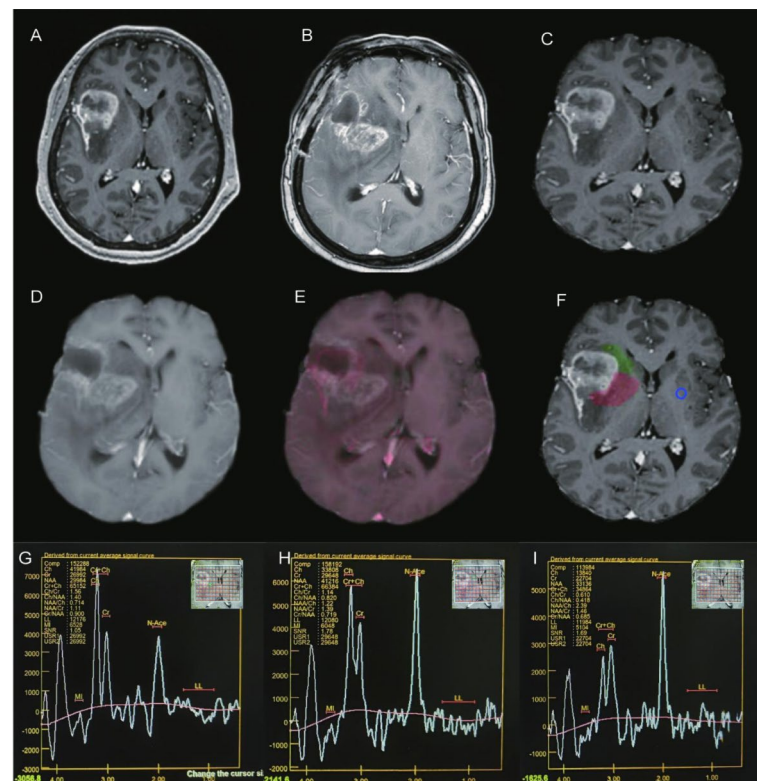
Use co-registration technology to register preoperative (A) and postoperative (B) MRI images. By registering the images (C, D, E), it is possible to further clarify the future tumor recurrence (F, red) and non tumor recurrence regions (F, green) in the NEPTRs, and thus obtain ¹H-MRS parameters for different regions (G: future tumor recurrence; H: non tumor recurrence regions, I: normal control regions, blue).
